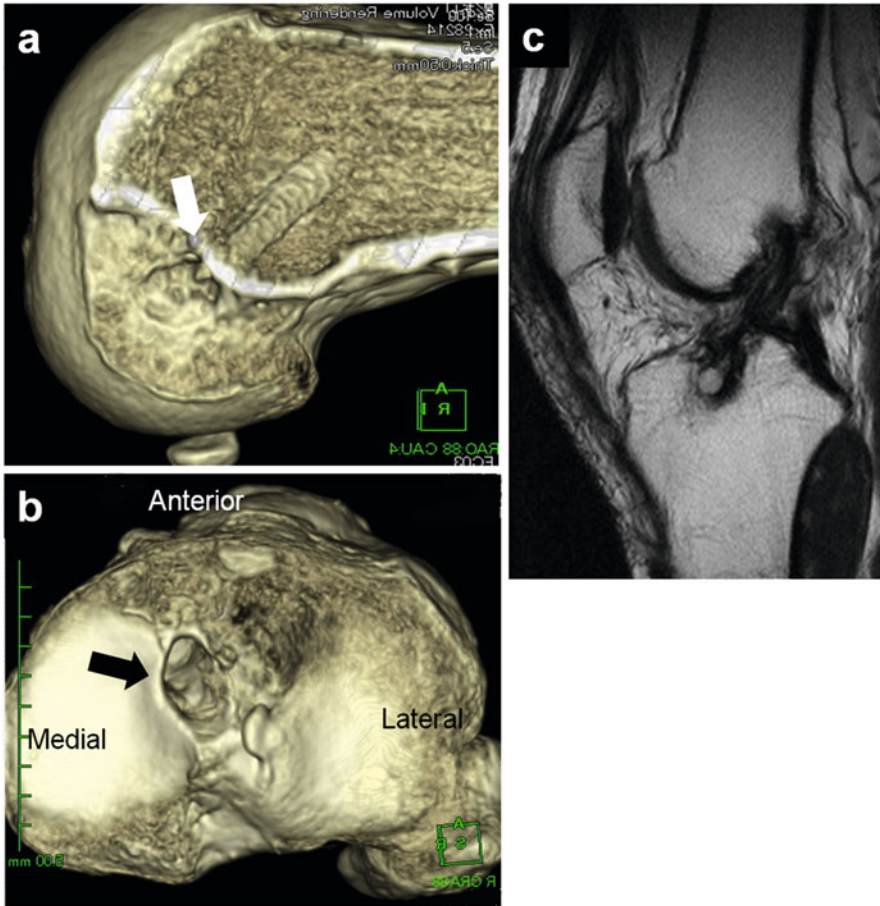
A case with residual instability after nonanatomic single-bundle ACL reconstruction, without graft tear by obvious reinjury. (a, b) Femoral tunnel position (a, white arrow) and tibial tunnel position (b, black arrow) in three-dimensional computed tomography. (c) Magnetic resonance imaging (sagittal view). The femoral tunnel was made at the “high noon” position on the lateral wall of the intercondylar notch. Tibial tunnel was placed posteriorly to avoid graft impingement. However, normal restoration of the knee kinematics and stability would be impaired with such a “vertical graft placement”
